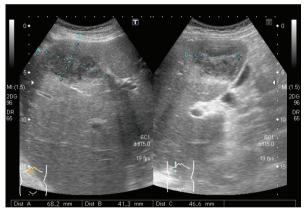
Abdominal sonography with a positive finding of abscess formation (68.2 mm x 41.3 mm x 46.6 mm) at the left liver lobe.
